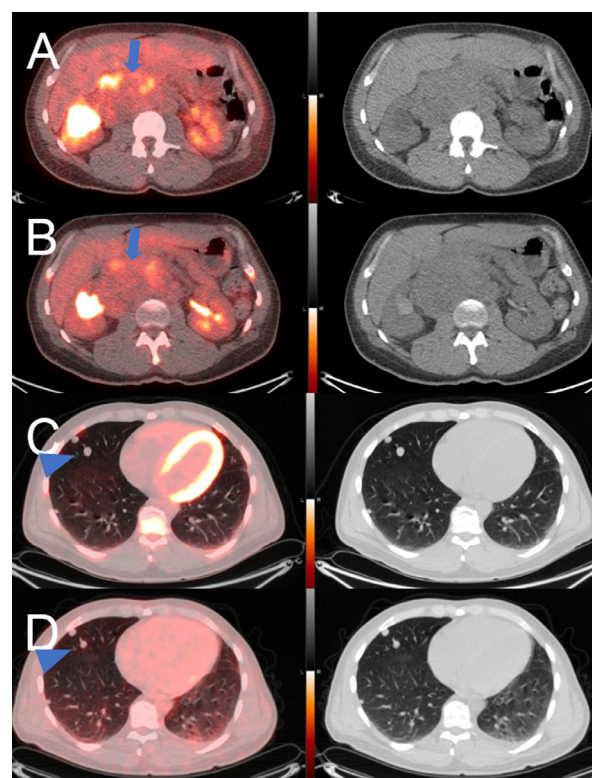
A 33-year-old man underwent orchidectomy for a mixed germ cell tumor with extensive tumor necrosis (60% seminoma, 30% teratoma, and 10% yolk sac tumor) and was known to have retroperitoneal and pulmonary metastases. Staging PET/neCT shows a heterogeneously FDG avid retroperitoneal mass measuring 12.2×6.4 cm with max. SUV 6.6 (A, axial images; arrow), reference liver SUV is 2.5; and bilateral pulmonary nodules measuring up to 1.2 cm with SUV 1.0 (C, axial images; arrowhead). Three months later, while on therapy with cisplatin, etoposide and ifosfamide, the size of the retroperitoneal mass is slightly increased, now measuring 13.3×7.8 cm (B, axial images; arrow), but the FDG uptake is decreased by 46%. The pulmonary nodules are not significantly changed in size or metabolic activity (D, axial images; arrowhead). The patient died nine months later.
